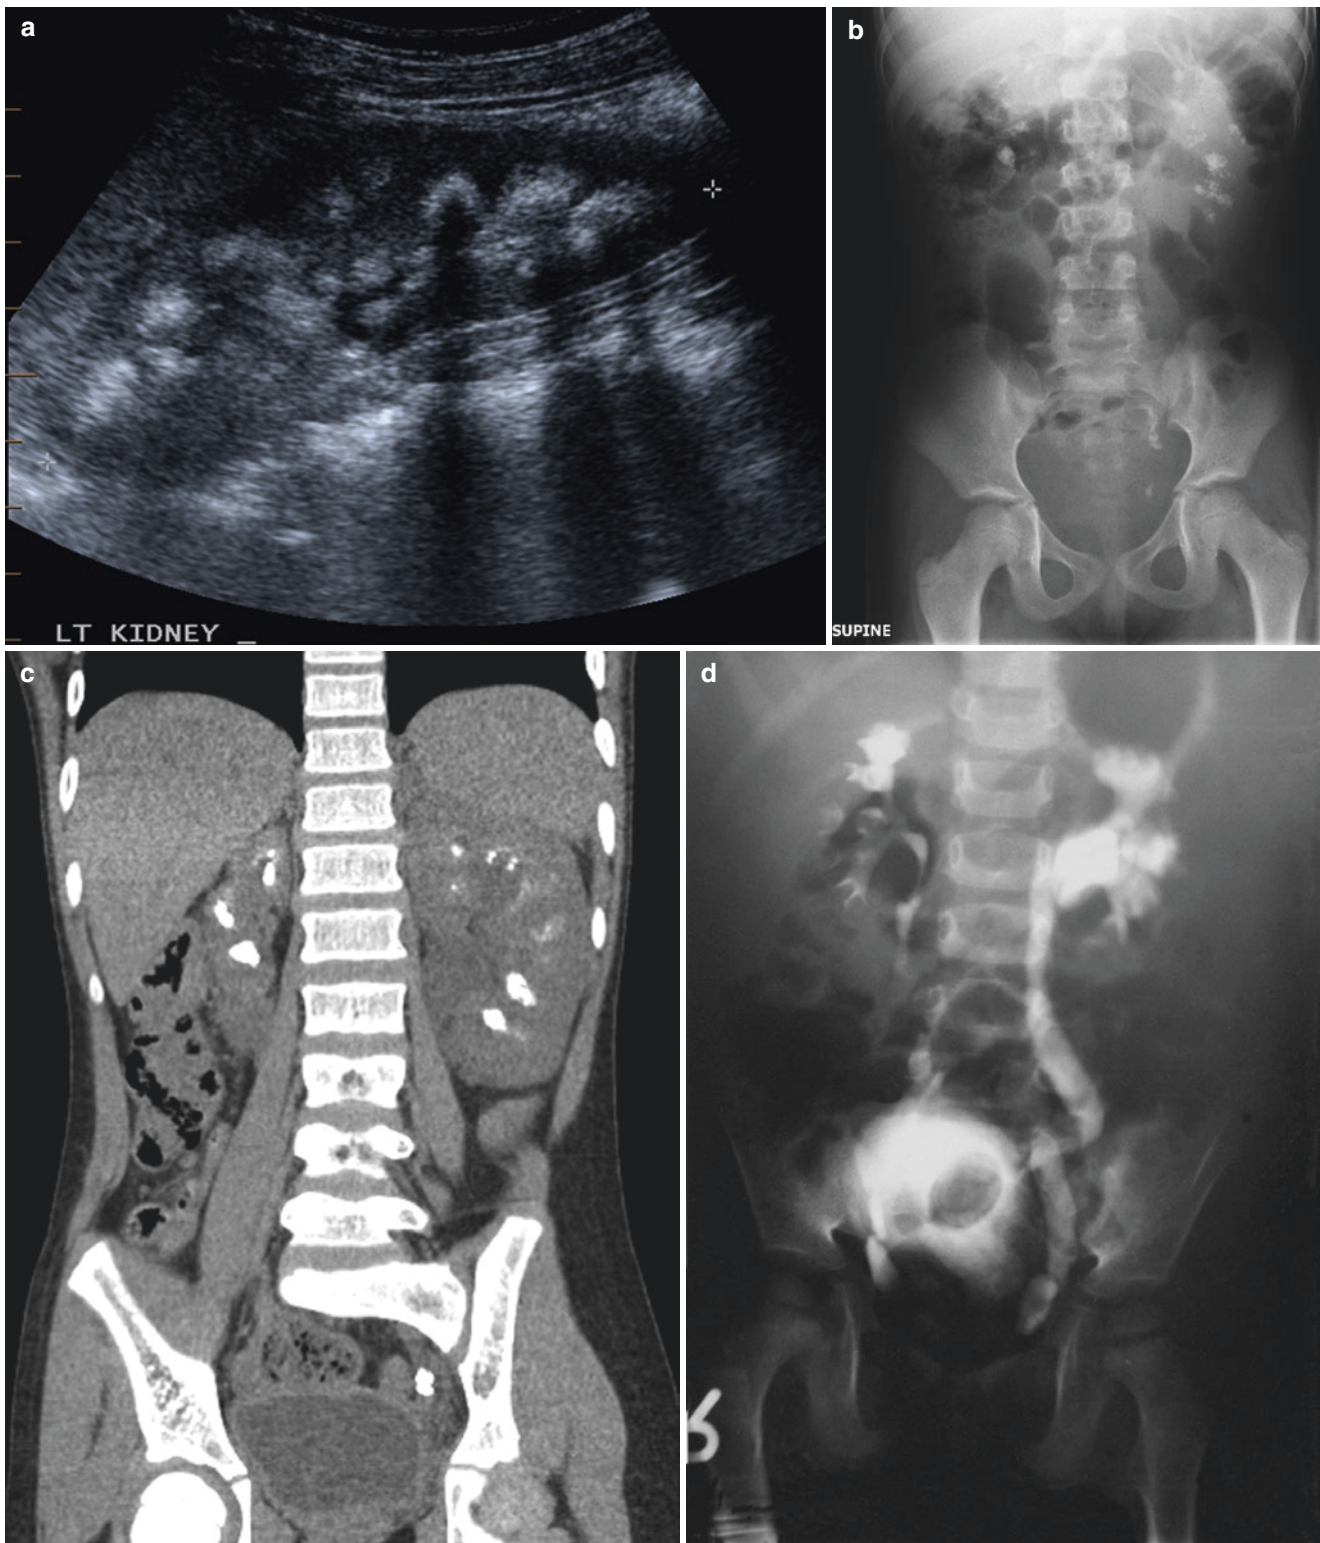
(a) Longitudinal ultrasound image of the kidney in a patient with renal tubular acidosis, demonstrating multiple renal calcifications. The calcifications are echogenic and demonstrate posterior acoustic shadowing. (b) Plain X-ray of the same patient as in (a), demonstrating multiple calcifications overlying the renal shadows with calculi present
